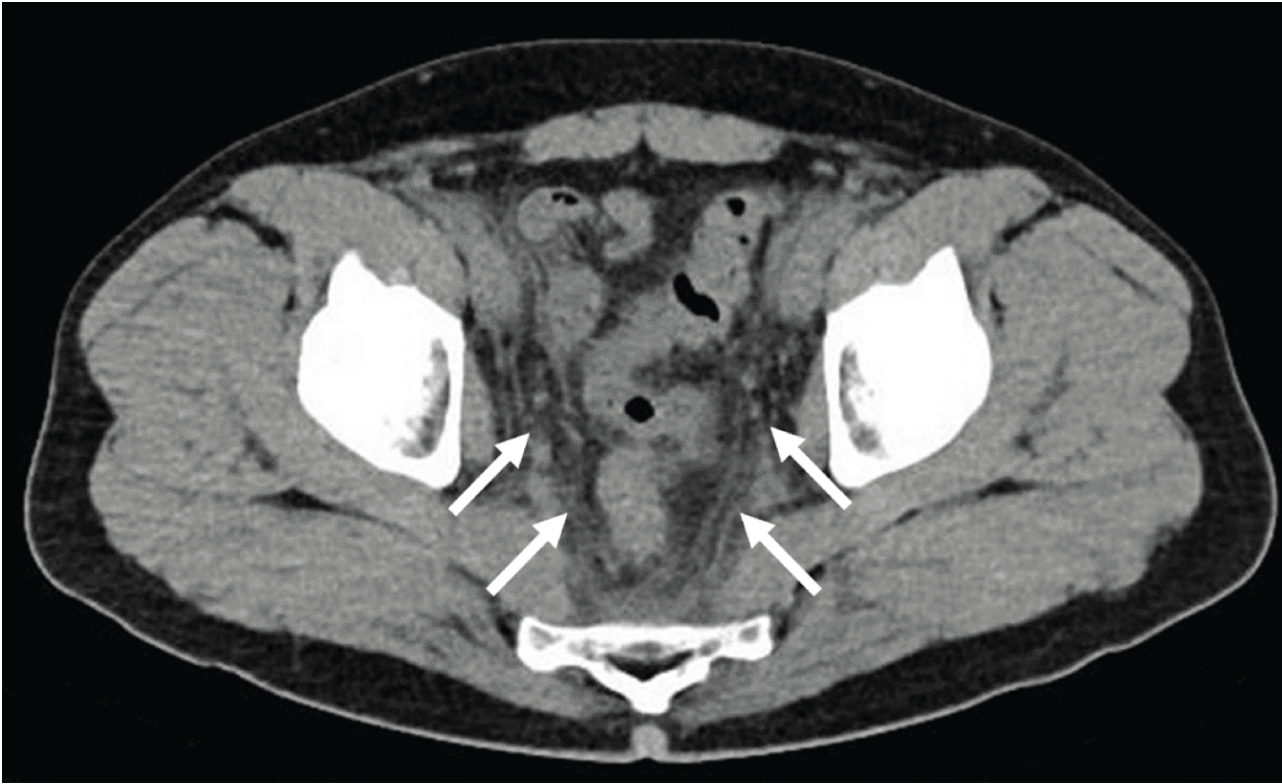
A plain abdominal computed tomography scan shows opacity in the pelvic fat tissue and peritoneal thickening (arrows) without free air, bowel oedema, or ascites.
